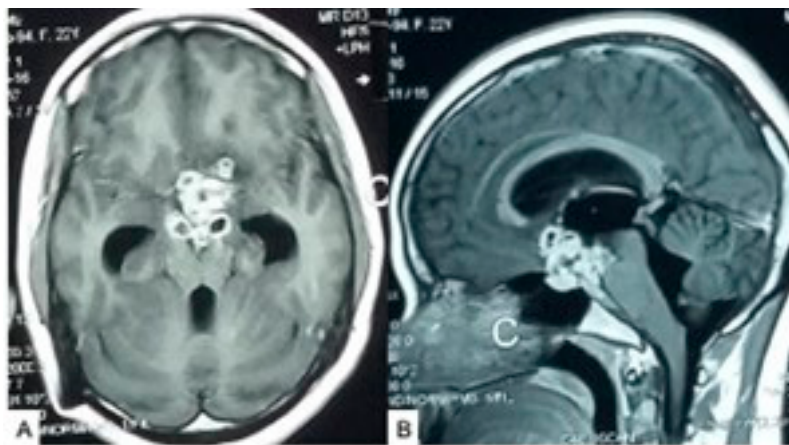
Multiloculated tuberculoma on a contrast-enhanced MRI (A,B). Source: Figure by authors.
